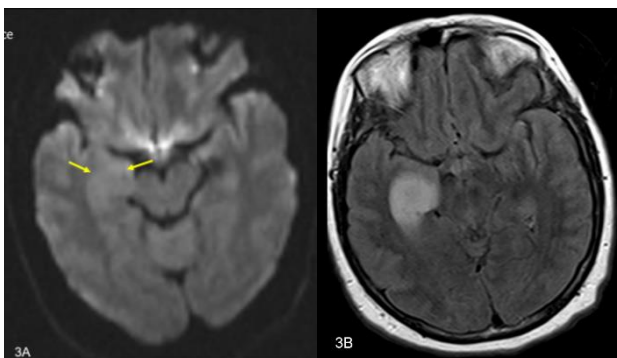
A) A 45-year-old female patient with a homogeneous hyperintense mass in the parahippocampal gyrus in the right medial temporal lobe on the diffusion-weighted image (arrows), and B) T2-weighted sequence image, pathology: glioblastoma
